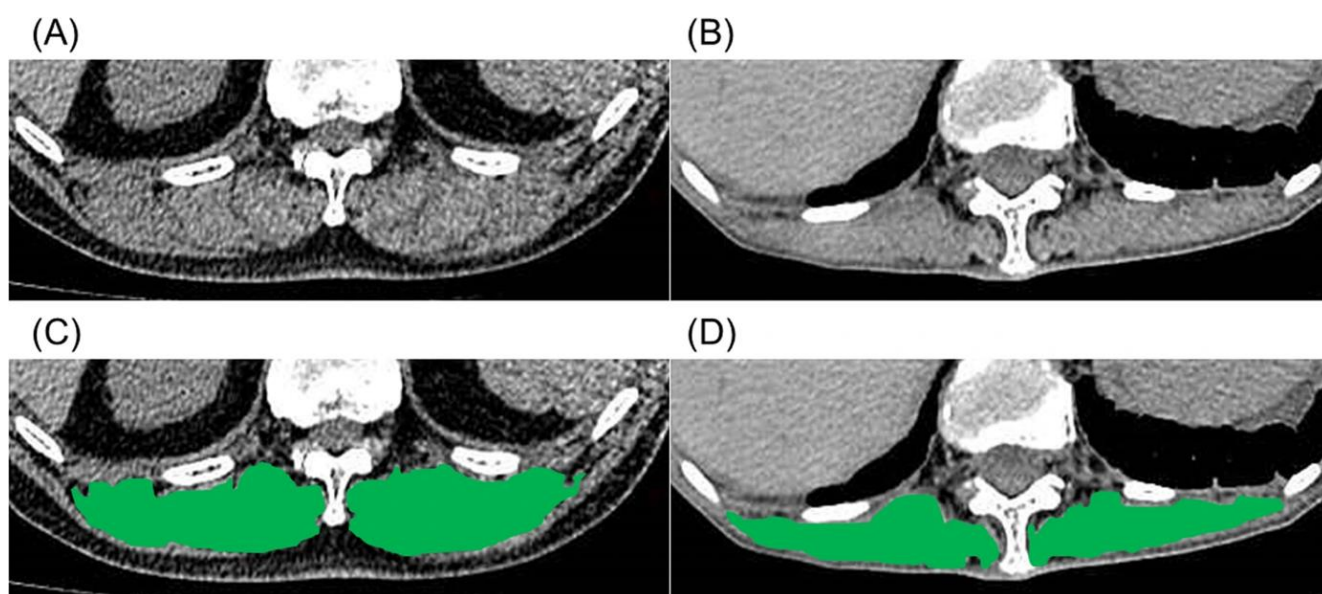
Representative computed tomography images used to measure the cross-sectional area of the erector spinae muscles (A, B).
